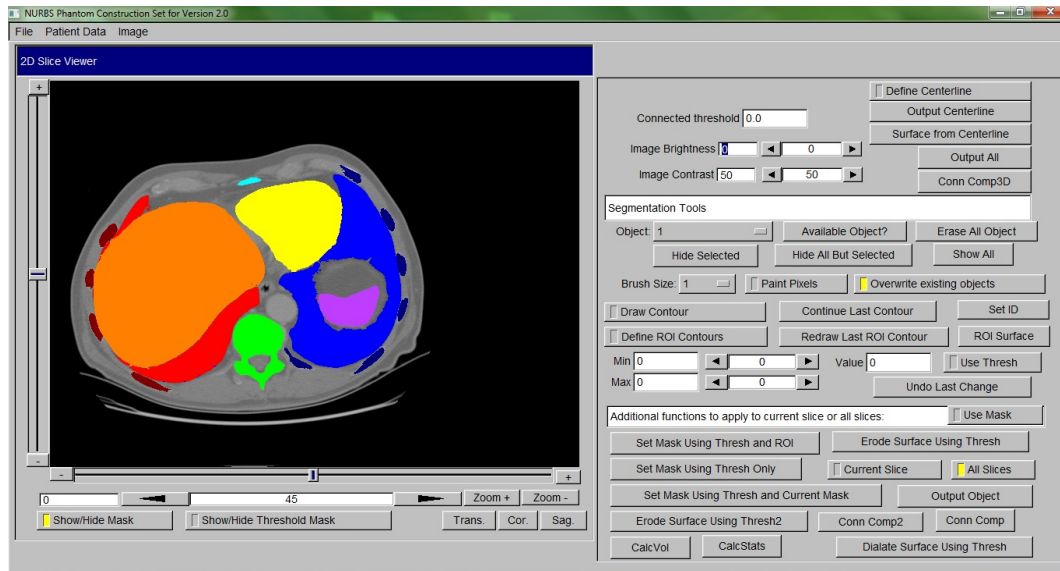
GUI used for segmenting organs from patient CT data. Each color corresponds to a different organ mask [20].
